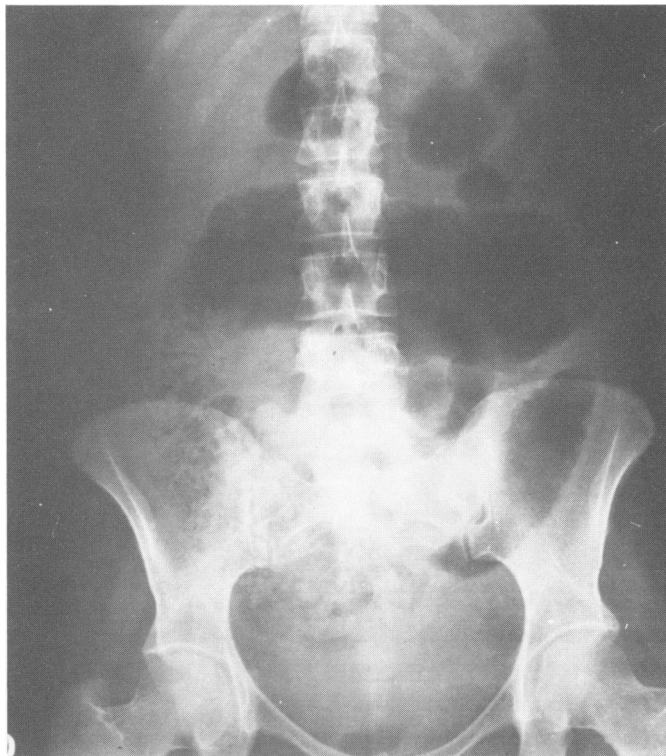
Roentgenogram of the abdomen in patient A. J. H. during fourth hospital week. Toxic dilatation developed while on continuous intensive medical therapy including steroids and ACTH infusions.
